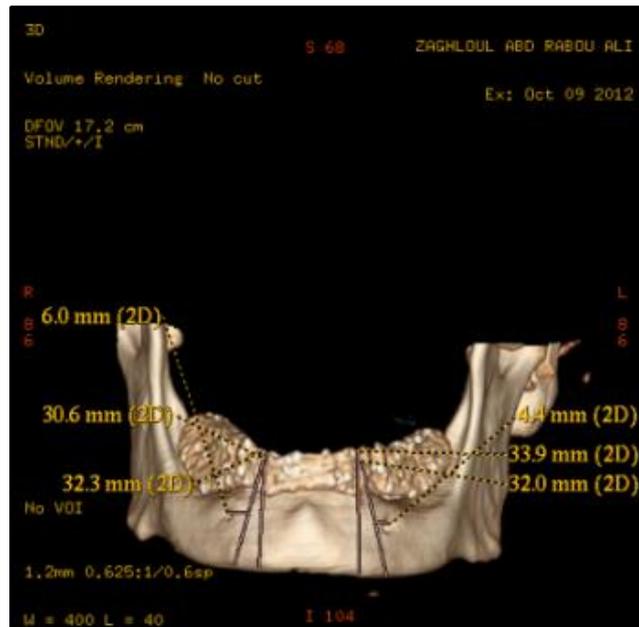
CT scan (5mm axial cuts) to detect the marginal bone height around each implant after surgery.
